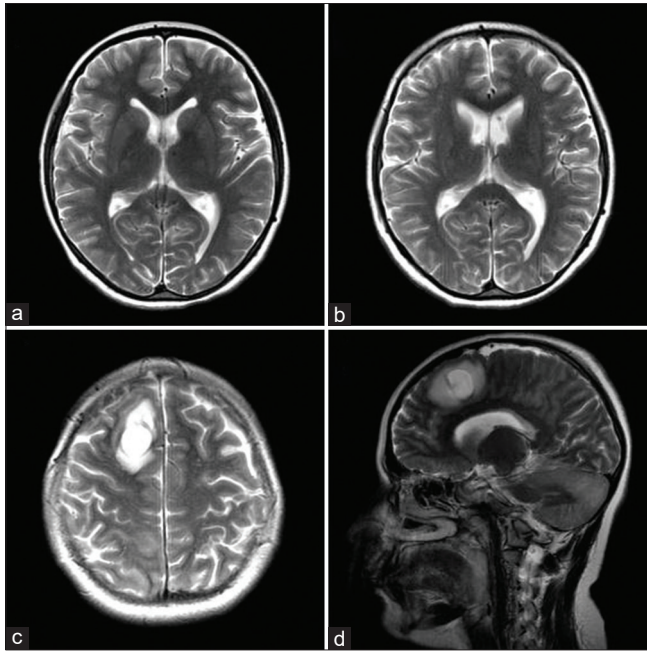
Imaging comparison. MRI at admission (before VPS surgery): (a) axial T2 view demonstrating no hydrocephalus. The lumbar puncture confirmed the diagnosis of idiopathic intracranial hypertension. MRI at revaluation (3 months later): (b) lower axial T2, (c) upper axial T2, and (d) parasagittal T2W1 views demonstrating the catheter pathway with an intraparenchymal pericatheter cyst and perilesional edema.
